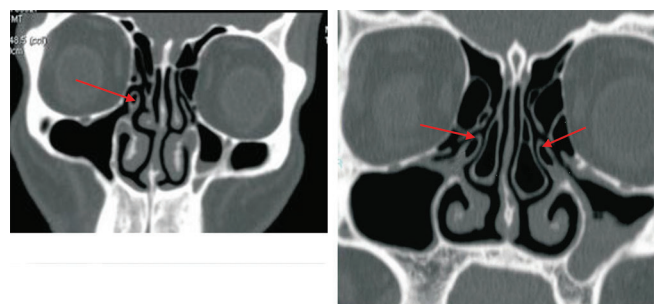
Coronal CT image showing unilateral extramural uncinat process (UP); Figure-2b: Coronal CT image showing bilateral extramural uncinat process
